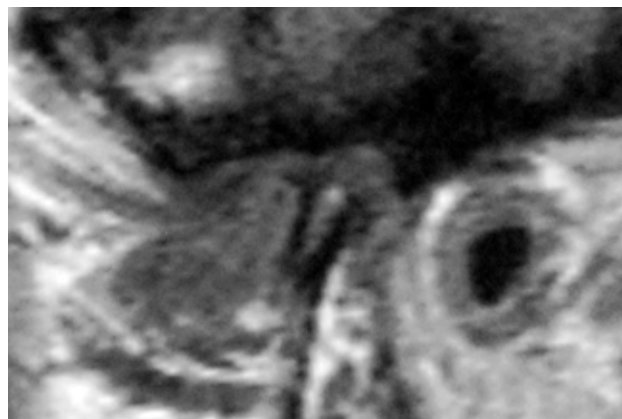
MRI of the right TMJ with the applied stabilization splint on a maxillary complete denture.
